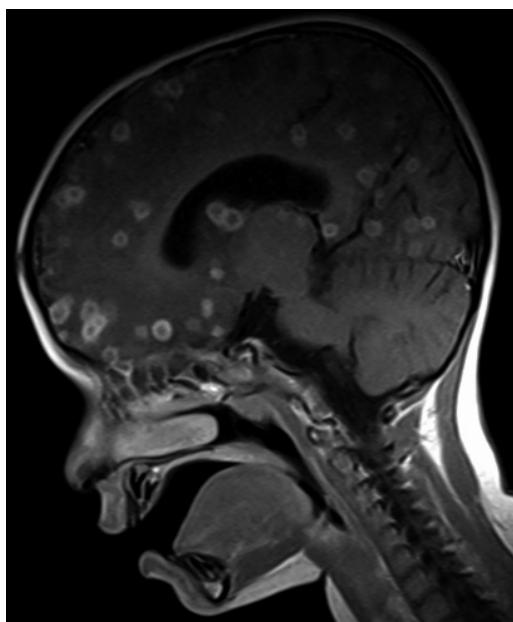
Magnetic resonance imaging of brain axial cuts showing multiple neurocysticercosis in the brain parenchyma, "starry-sky" appearance.
